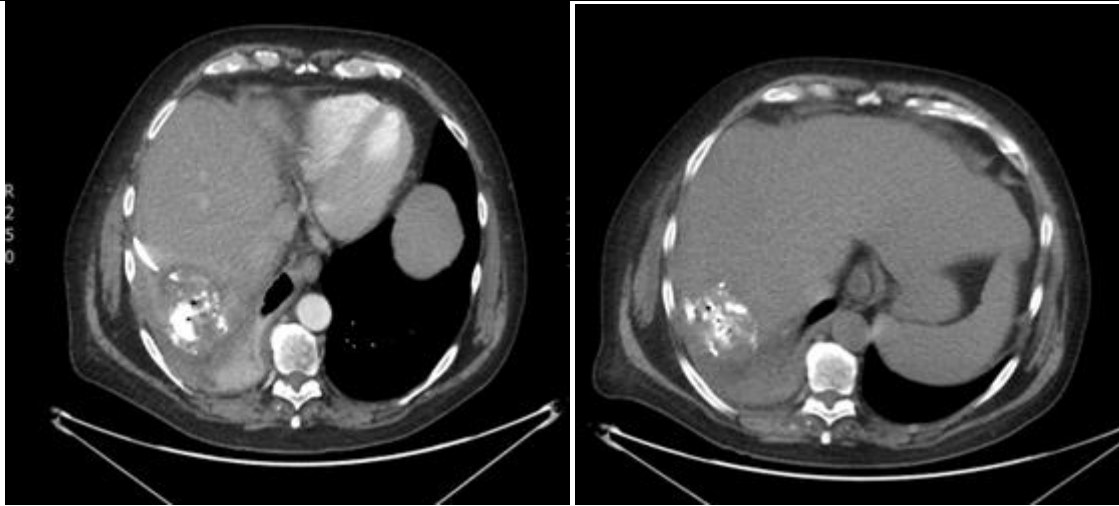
US and CT after 1 month from the placement of percutaneous drainage showed the detention of the collection, so the drainage was removed.
